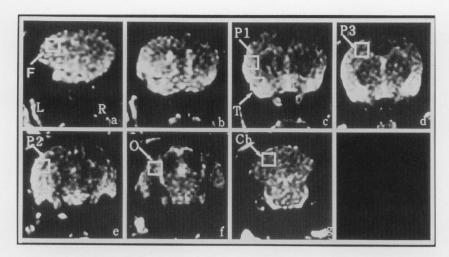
T2 weighted coronal MRI 1 wk after left MCA and CCA occlusion. Note that the hyperintense areas represent cerebral infarction. Each ROI of the ischemic core (temporal region; T), the peri-infarct areas (proximal parietal region; P1, middle parietal region; P2, distal parietal region; P3), the intrahemispheric remote areas (frontal region; F, occipital region; O), and remote area (cerebellum; Cb) was shown.
